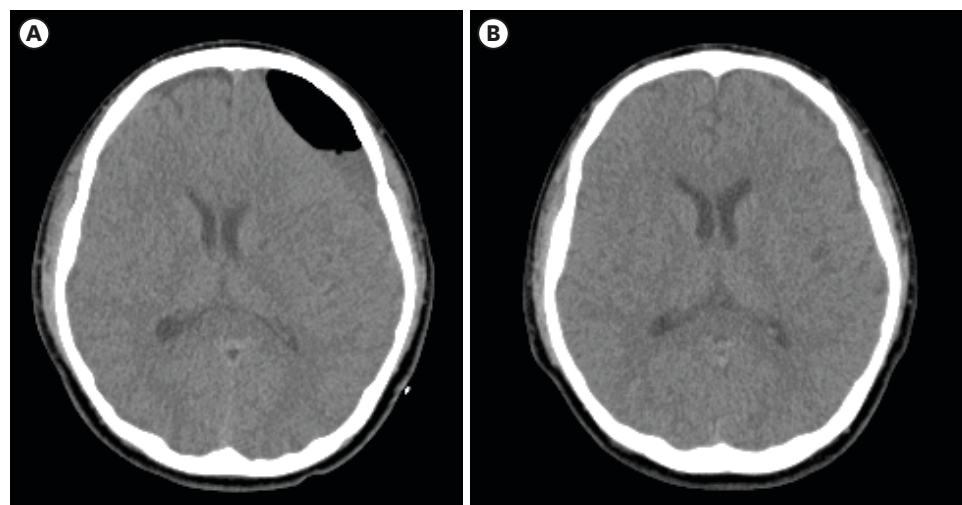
(A) Postoperative brain CT scan showing resolved chronic SDH in left cerebral hemisphere. (B) One-month brain CT scan showing near-completely improved state. CT: computed tomography.
